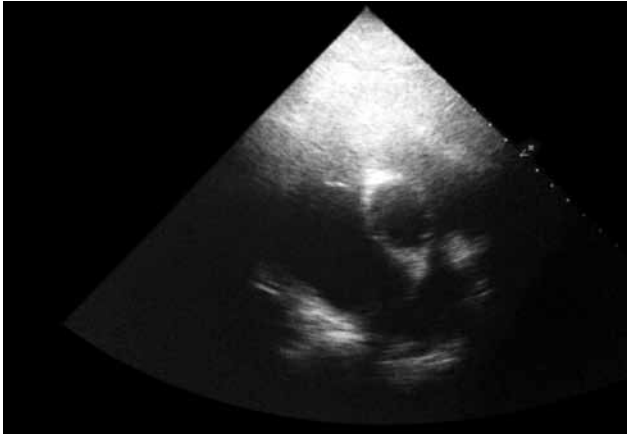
Transthoracic echocardiography (long-axis view) showing the device migration in the main pulmonary artery.
